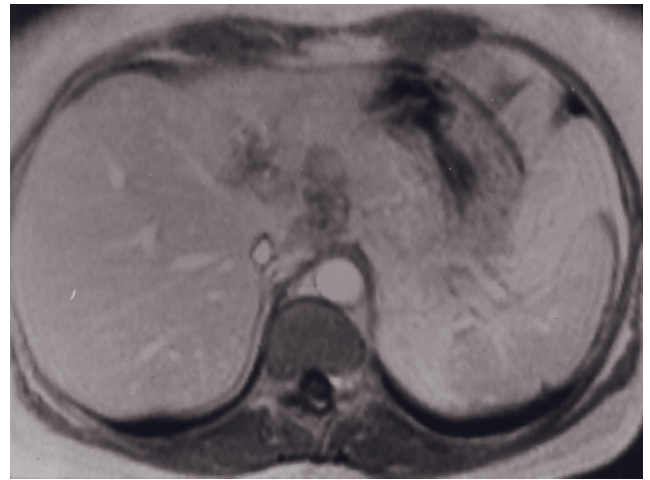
Arterio-venous malformation in Rendu-Osler-Weber syndrome. T2-weighted fat-suppressed ETSE (a) and immediate postgadolinium SGE (b) images in a patient with Rendu-Osler-Weber Syndrome. There are multiple varying-sized liver lesions, many of which demonstrate intense enhancement on immediate postgadolinium images (b), representing arterio-venous malformation. Some lesions are low signal on T2 (a) and postgadolinium (b) images, consistent with hemorrhage and thrombosis.
